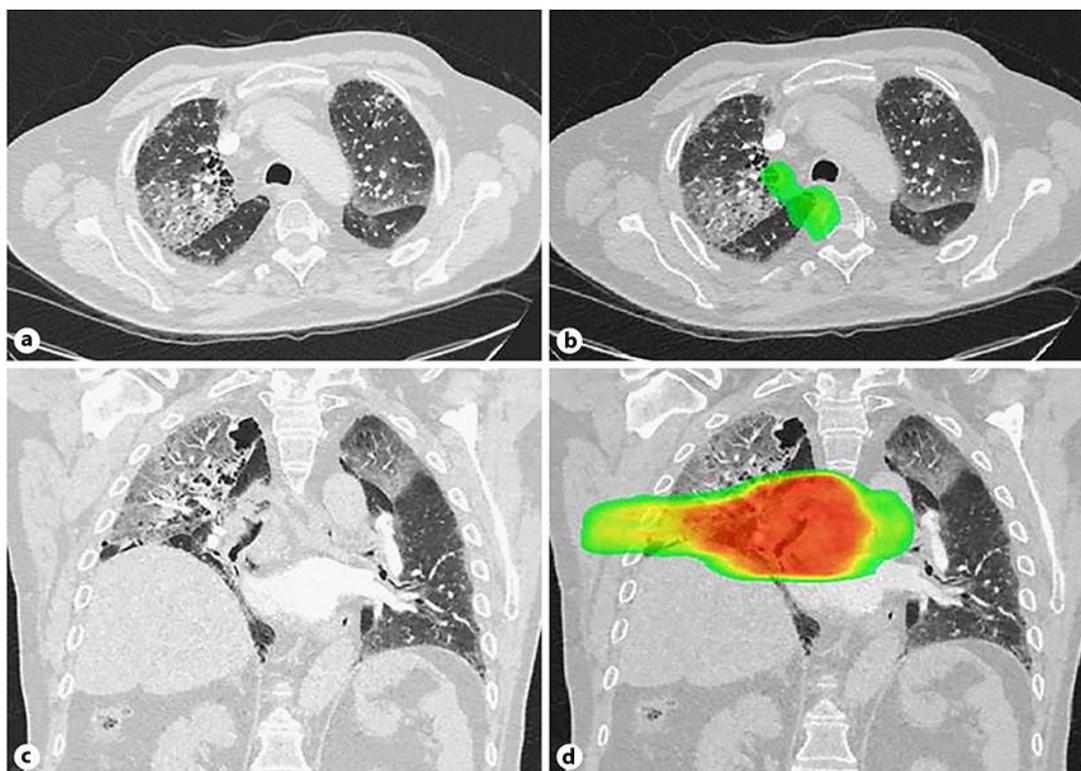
a Axial Computed Tomography scan showing bilateral infiltration, with diffuse ground-glass opacities. b Axial Computed Tomography scan with irradiated overlay, showing bilateral infiltration extending beyond the previously irradiated field (colored area in green). c Coronal Computed Tomography scan, showing bilateral infiltration, with diffuse ground-glass opacities. d Coronal Computed Tomography scan with irradiated overlay, showing bilateral infiltration extending beyond the previously irradiated field (colored area, red highest dosage, green lower dosage).
